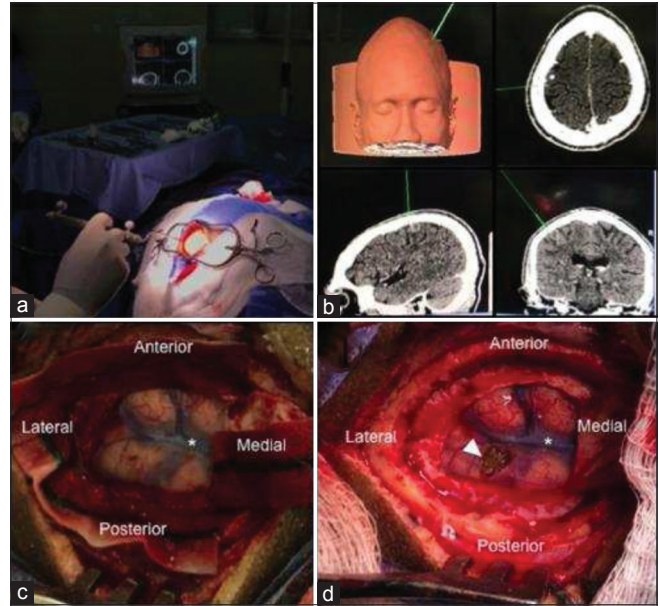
Surgical steps of open brain lesion removal using computed tomography-guided navigated transcranial magnetic stimulation. (a) Localizing craniotomy site guided by neuronavigation system. (b) Neuronavigation system image could precisely localize lesion. (c) After durotomy, we exposed the eloquent cortex and lesion site. Asterisk represents a cortical vein on central sulcus between motor and somatosensory cortex. (d) Final aspect after complete lesion removal as seen in arrowhead.
